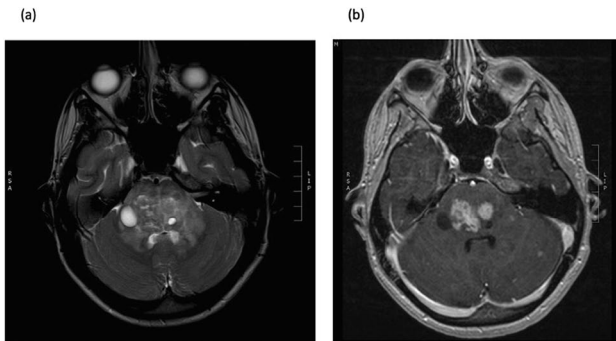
MR images of a patient with ECD and infratentorial involvement depict high signal intensity on T2-weighted images with small cystic components (a) and heterogeneous enhancement on contrast-enhanced T1 weighted images (b).
